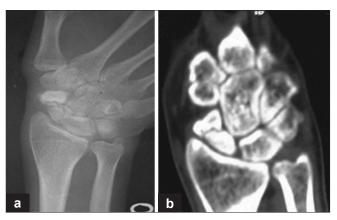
(a) X-ray wrist joint anteroposterior view in ulnar deviation showing nonunion with avascular necrosis of distal pole of scaphoid (b) CT scan confirming the nonunion and a sclerotic distal fragment
